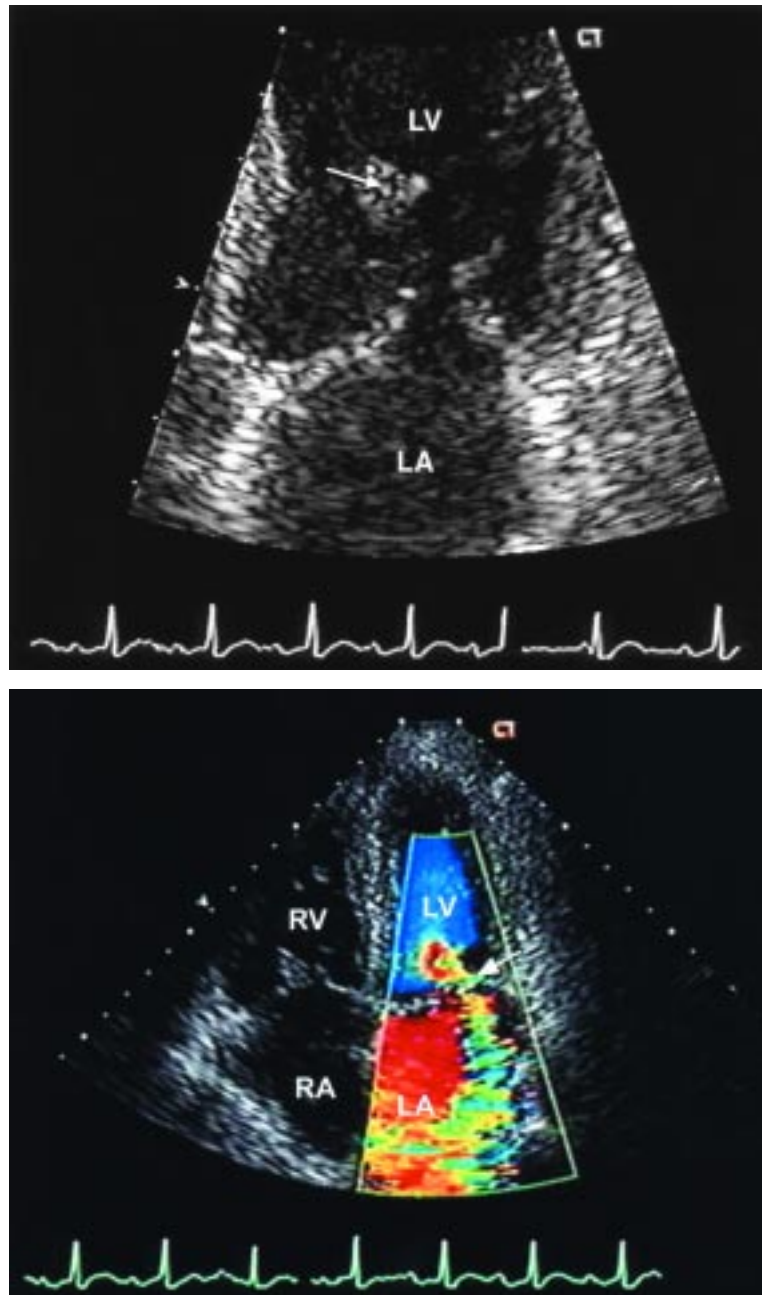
Top, transthoracic apical four-chamber view (LA = left atrium, LV = left ventricle) with a close-up of the mitral valve apparatus in diastole showing the ruptured anterolateral papillary muscle attached to the anterior mitral leaflet (arrow). Bottom, transthoracic apical four-chamber view with color flow imaging showing severe mitral regurgitation (arrow) (LA = left atrium, LV = left ventricle, RA = right atrium, RV = right ventricle).
